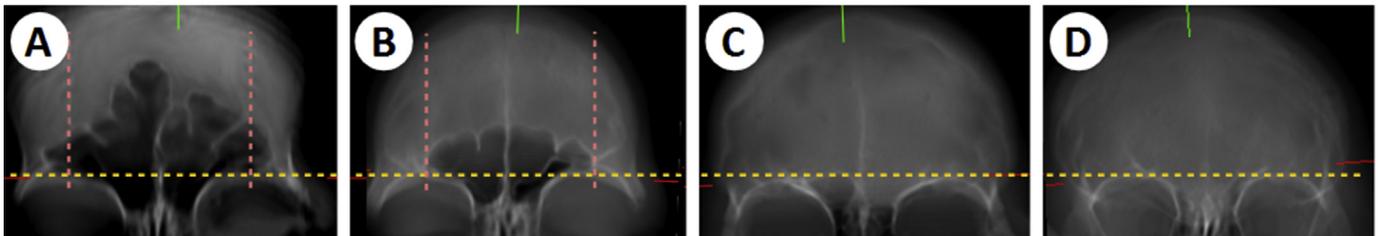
Guerram's classification (Guerram et al., 2014) of frontal sinus size by using Schmittbuhl and Le Minor's supraorbital line (SOL; yellow dotted) as reference (Schmittbuhl and Le Minor, 1998) and the additionally introduced midorbital reference line (MOL; red dotted); sinus types: hyperplasia, sinus extent lateral to MOL (A); medium-size, sinus extent within MOL and above SOL (B); hypoplasia, sinus extent below SOL (C); and aplasia, no radiologic sign of frontal sinus (D); CT images are shown in reconstructed coronal x-ray view.
